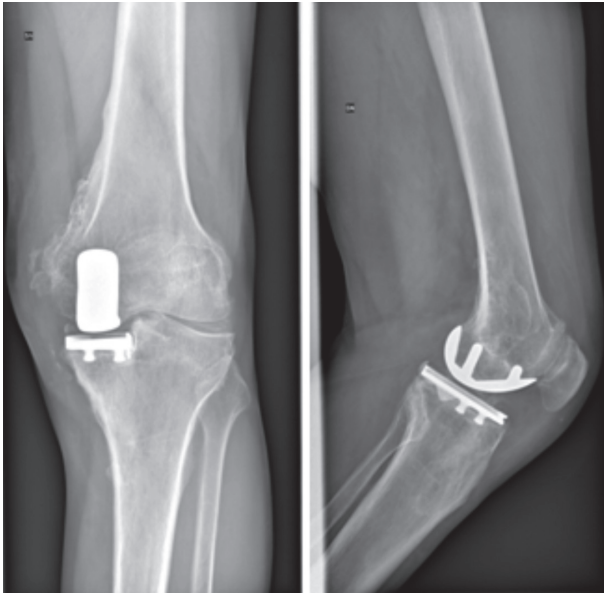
Radiographs of the left knee following UKA implantation after 2 year of replacement
